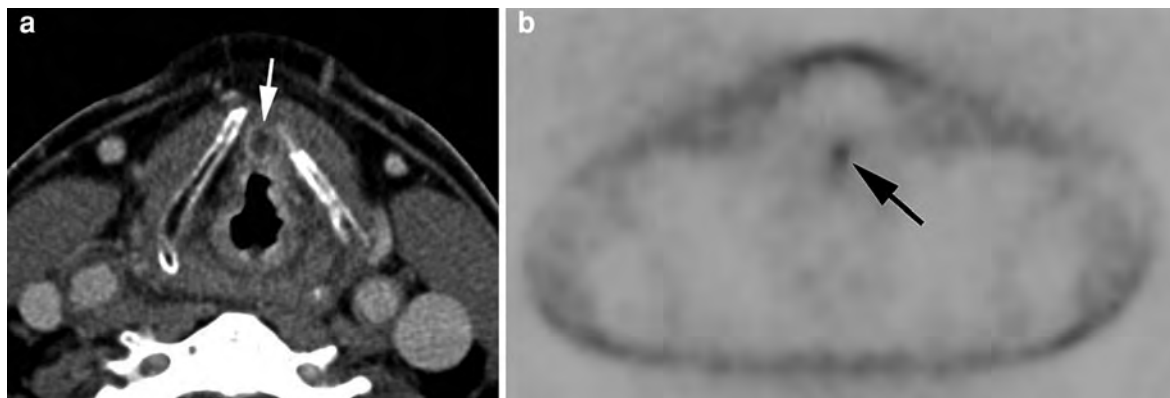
Same patient as in Fig. 16. Six months after radiotherapy, clinical suspicion of tumor recurrence. a Axial contrast-enhanced CT-image shows centrally hypodense nodular lesion in the preepiglottic space (*arrow*) suggesting necrotic tumor.
